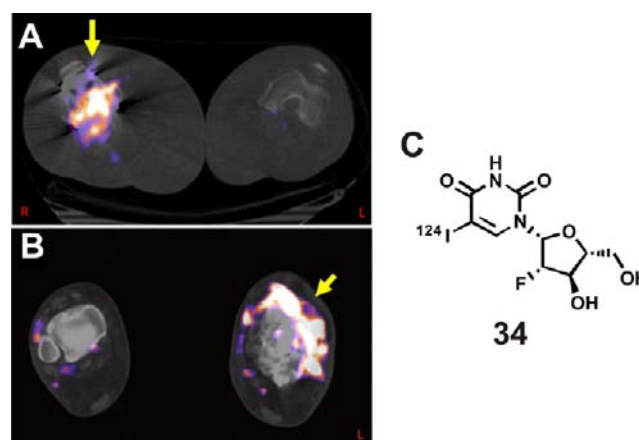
PET/CT scans of septic arthritis (MRSA) in the right knee (a) and cellulitis (multiple bacterial strains) in the left lower extremity (b) 2 h after IV injection of 74 MBq of [¹²⁴I]FIAU. (Reprinted from Diaz et al. *PLoS ONE* 2007, 2(10), e1007.)
